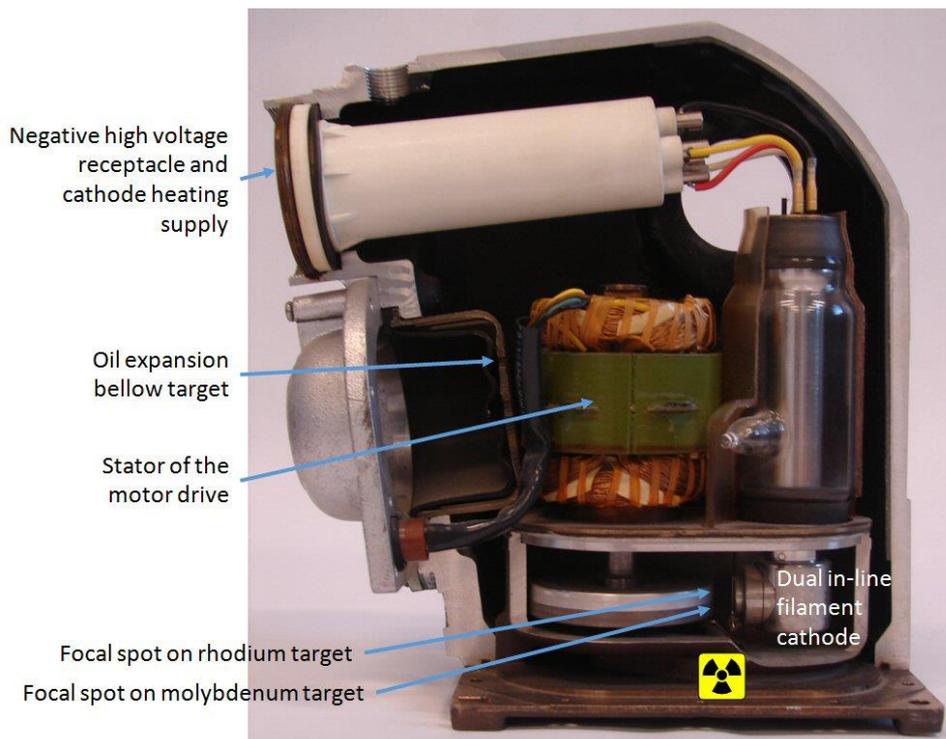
GE DMR mammography tube assembly. X-ray focal spots on molybdenum and rhodium targets positioned at the perimeter of the anode. (Photo courtesy of GE.)
